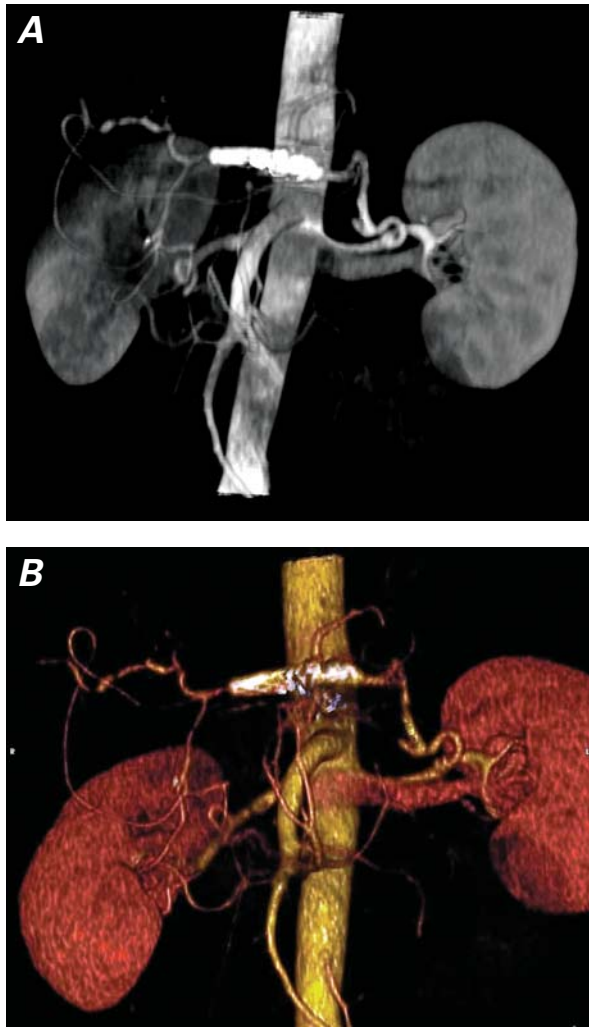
At 12 postoperative months, A) multiplanar reformation computed tomographic reconstruction shows complete exclusion of the aneurysm with a spleno-hepatic stent-graft and patency of the reno-splenic bypass. B) Three-dimensional computed tomographic reconstruction shows the new anatomy of the postoperative visceral vessels.
